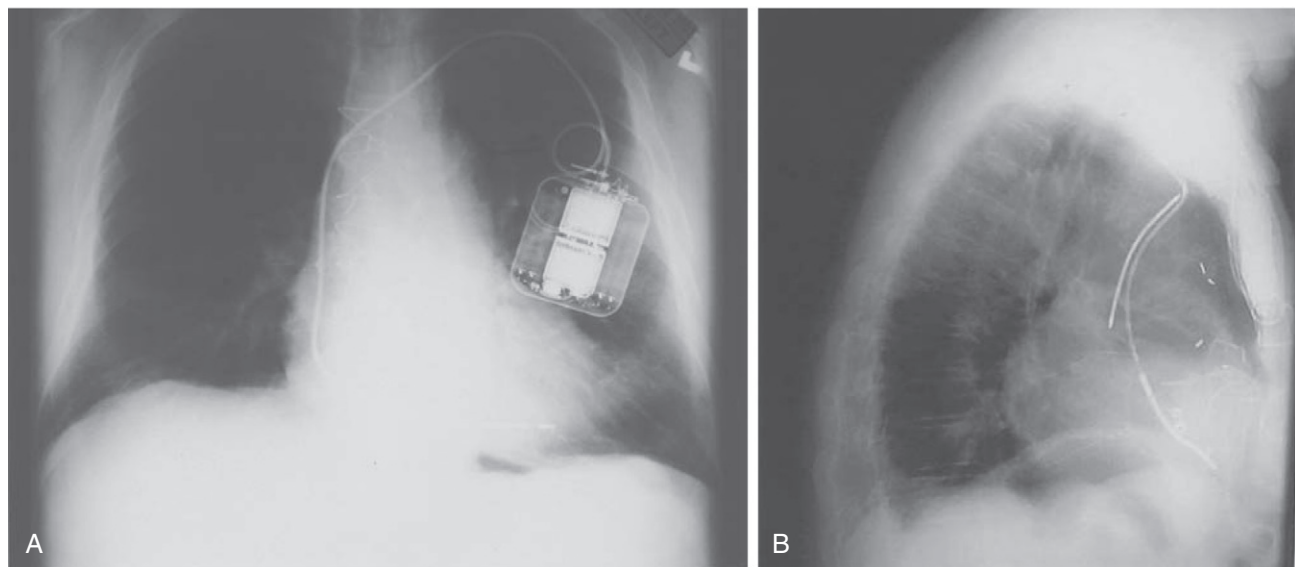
A, Chest radiograph (posteroanterior view) of a single-chamber ventricular implantable cardioverter-defibrillator (ICD) with single right ventricular pacing and defibrillation lead. B, Chest radiograph (lateral view) of single-chamber ventricular ICD with additional defibrillation lead in the superior vena cava. Today, dual-coil leads avoid the need for this additional lead.
